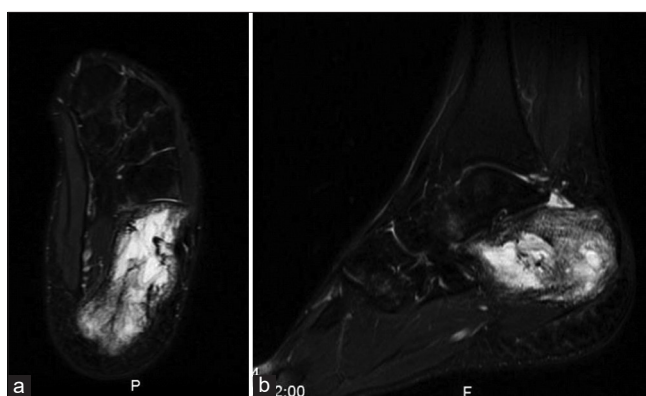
Magnetic resonance imaging (a) axial view showing intramedullary space occupying lesion involving almost all of the calcaneus, with a small lateral extraosseous soft-tissue component. (b) Sagittal cuts showing intramedullary space occupying lesion involving almost all of the calcaneus, with a small lateral extraosseous soft-tissue component.
